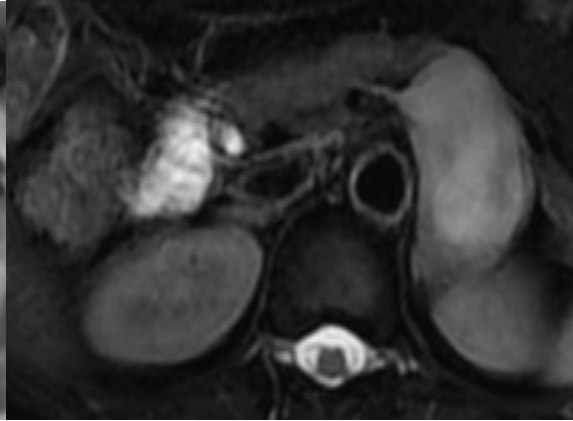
Abdominal contrast-enhanced magnetic resonance images
